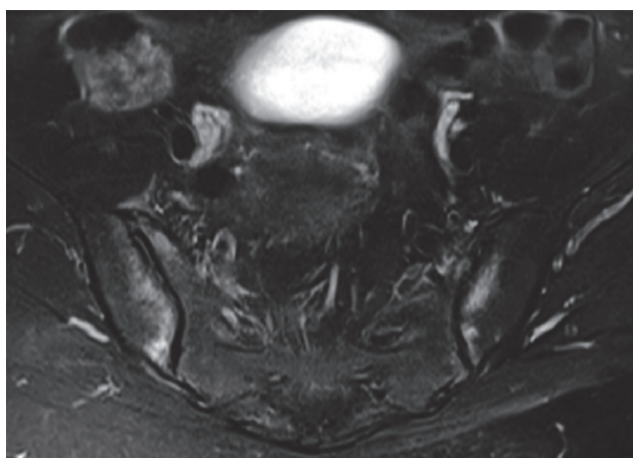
Contrast enhanced fat-sat T1-weighted image shows enhancement in bilateral sacroiliac joints
